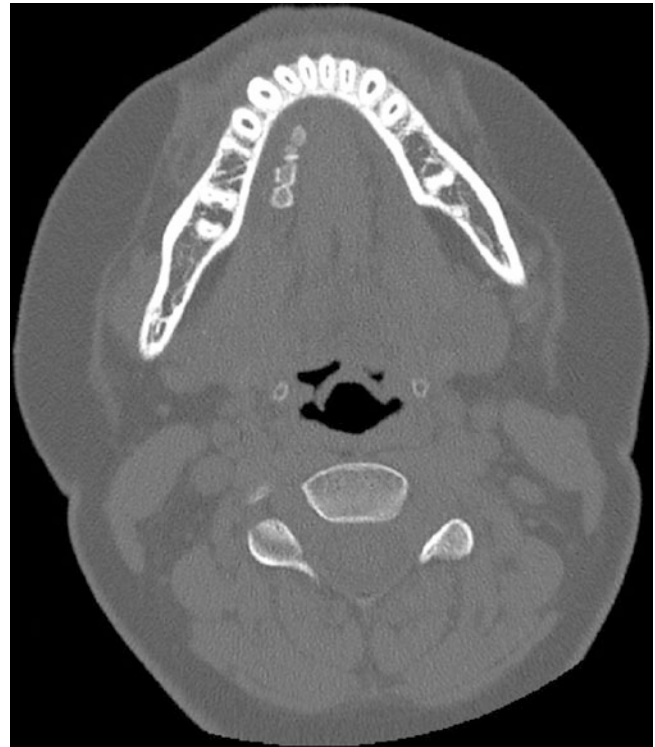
Axial CT image shows a row of calculi within the right submandibular gland duct
